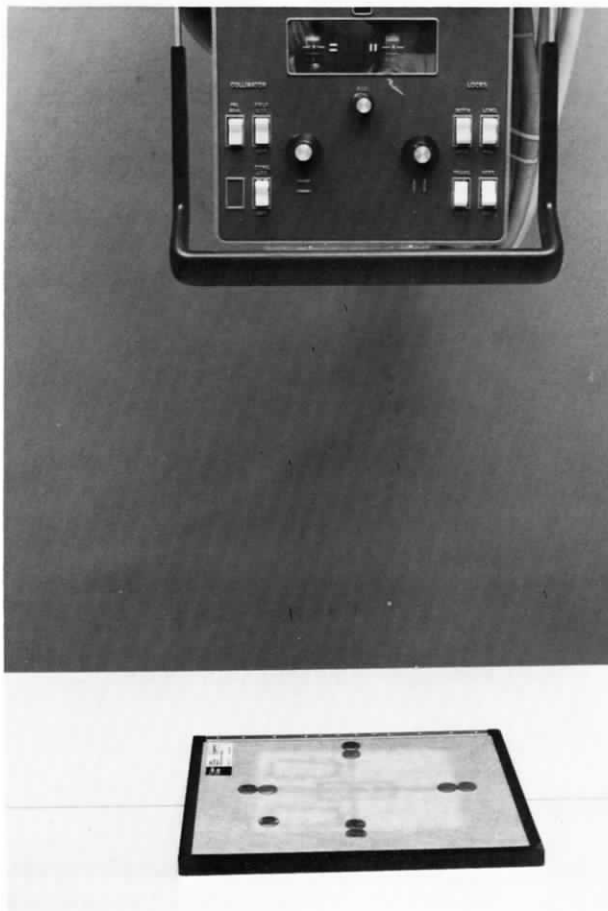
X-ray field-light field congruence test setup. The nine-penny test uses the ninth penny to indicate the orientation of the cassette relative to the x-ray-light field.
